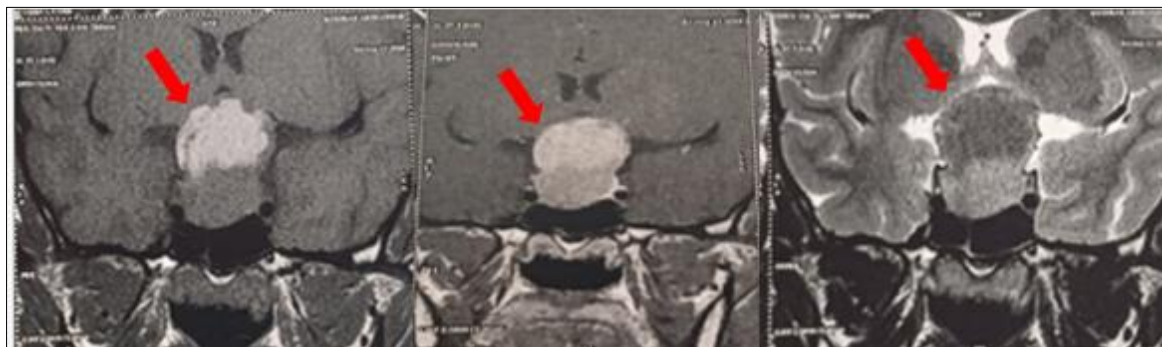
Preoperative coronal T1- and T2 weighted magnetic resonance imaging pituitary revealing an expansive sellar and suprasellar mass measuring 125 × 97 × 60 mm exerting compressive effects and displacing the cavernous sinuses and the optic chiasm, consistent with a pituitary macroadenoma exhibiting necrotic and hemorrhagic remodeling
